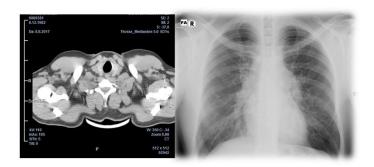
Chest CT and X-ray showing hilar arborization and prominant pulmonary artery with hilar micronodules
